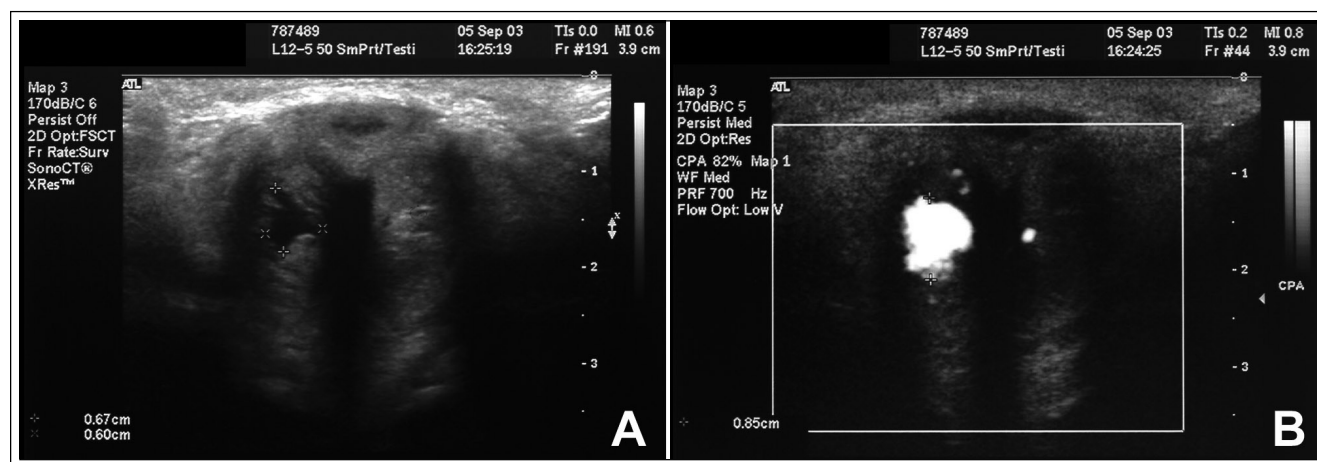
Ultrasound imaging of the proximal penis. a) Gray-scale ultrasound shows an irregular cystic cavity (+) corresponding to the ruptured cavernous artery. b) Color Doppler ultrasound of an adjacent region confirms the high flow arterio-lacunar fistula (+) from the right cavernous artery.
